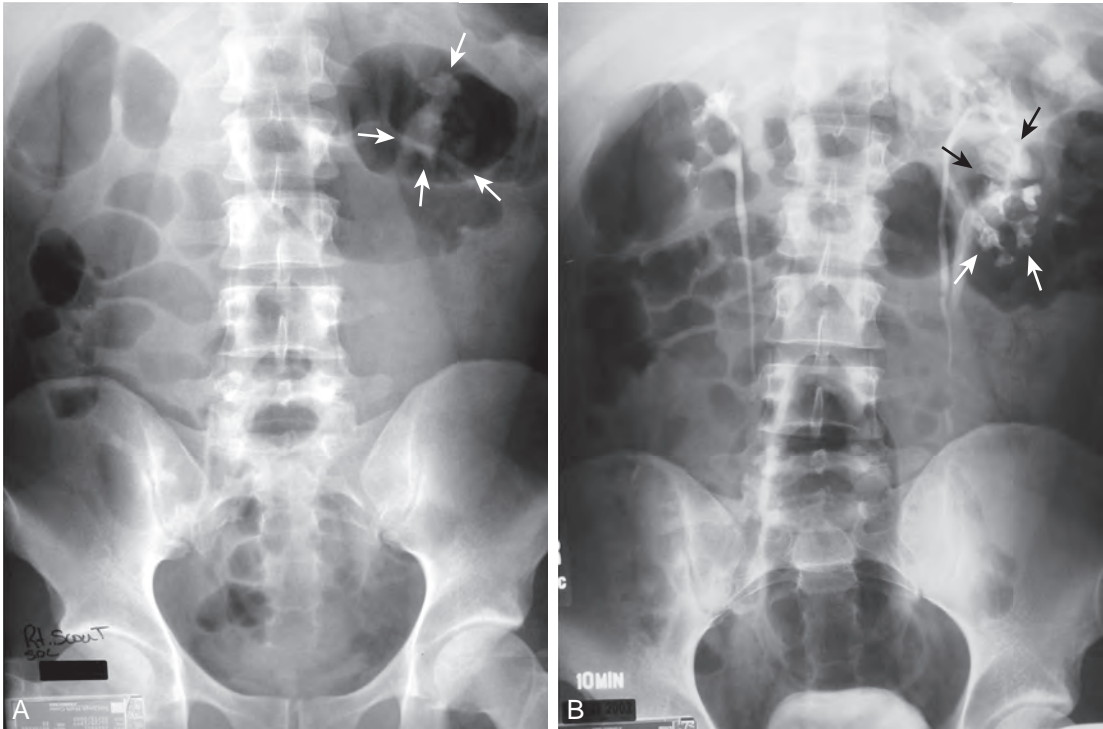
Cystine calculi are radiopaque on plain film, but are less dense than other calcium-based calculi. A, Note the stone (arrows) within the lower pole of this duplicated system. B, Similar to uric acid stones, the cystine calculus (arrows) is more clearly distinguished during the excretory phase of the intravenous pyelogram.
